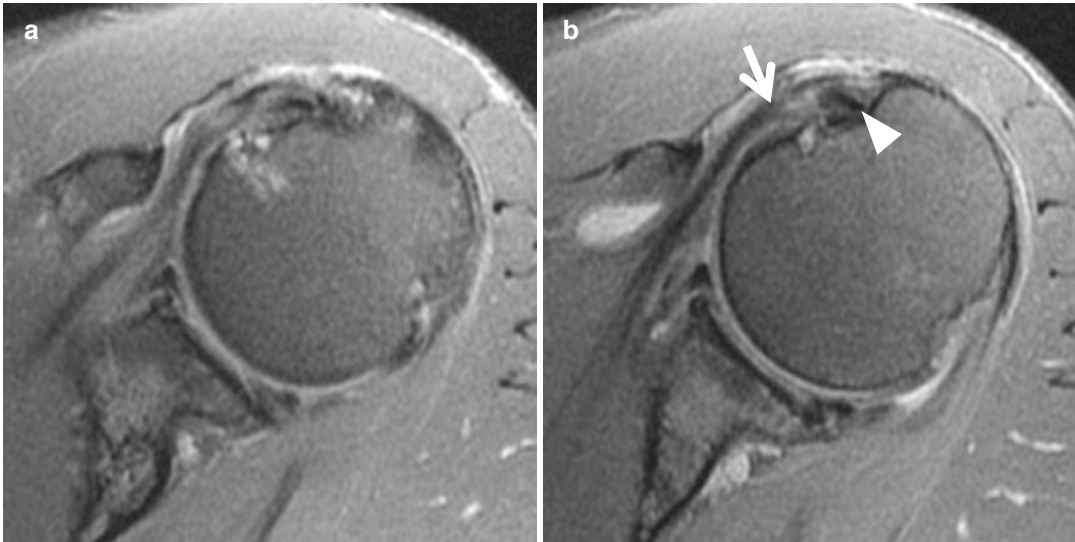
67-year-old man with left shoulder pain. (a and b) Axial intermediate-weighted MR images show a high-grade partial-thickness tear of the subscapularis tendon involving the articular side and lateral hood (arrow). The biceps tendon is also partially torn and medially subluxed
